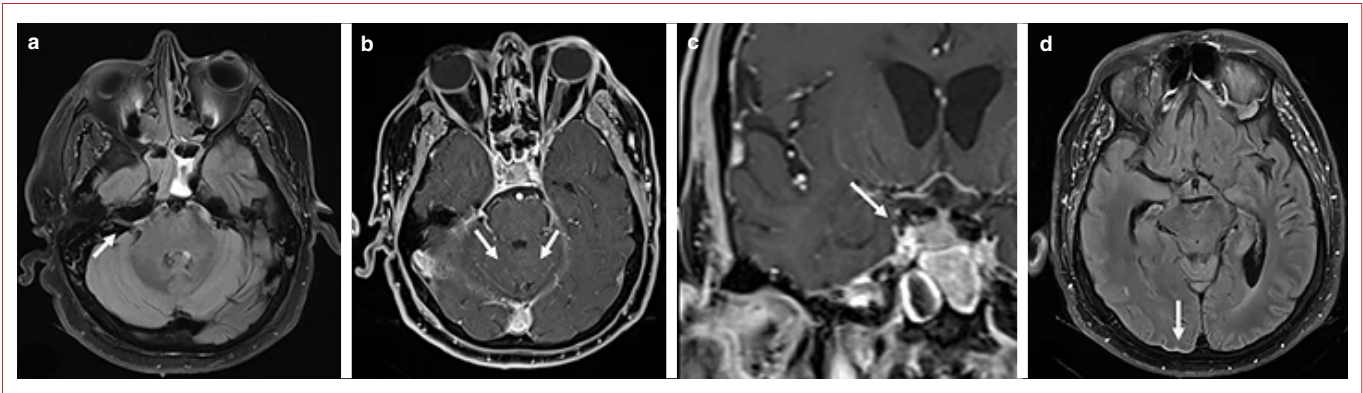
Postcontrast magnetic resonance imaging (MRI). (a) Post-contrast fluid-attenuated inversion recovery (FLAIR) scan shows focal perineural contrast enhancement in the right trigeminal nerve intracanalicular segment (arrow). (b) Post-contrast axial T1A series shows leptomeningeal contrast enhancement in the superior cerebellar follicles (arrow). (c) Post-contrast coronal T1A series shows contrast enhancement in the right oculomotor nerve cisternal segment (arrow). (d) Post-contrast FLAIR scan shows mild dural contrast enhancement in the right occipital convexity (arrow).
